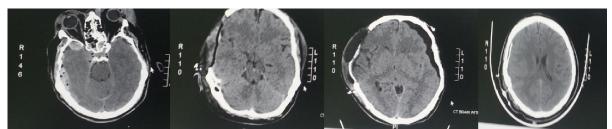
male patient 35 years old post MVA transferred to the hospital intubated and ventilated with GCS 8, CT brain picture1: shows right extradural hematoma pneumocephlous fracture base and SAH. Picture 2: shows post right frontotemproparietal craniectomy with evacuation of hematomas and release of pressure within3hours. Picture 3: CT brain after 2 weeks shows collection of subdural hygroma bilaterally picture 4: CT brain after 3 months shows bone flab replacement with resolved hygroma
